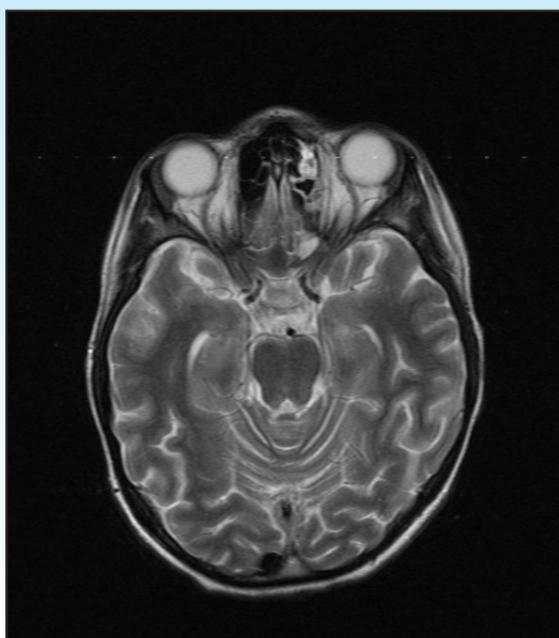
T2-weighted MRI brain showing mild atrophic changes and sinusitis.
